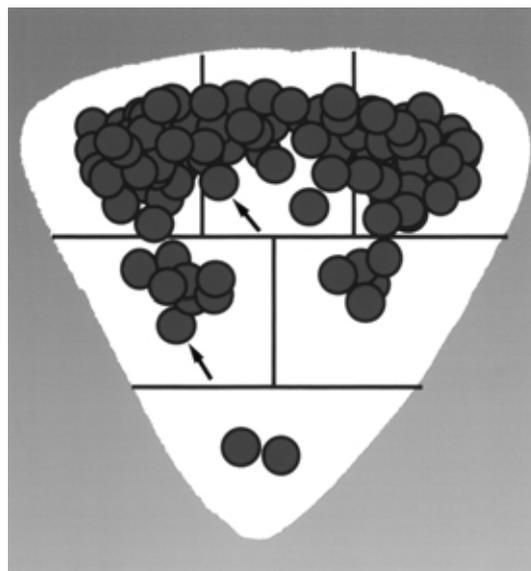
The location of E-GSs (arrows) was determined in a frontal view of the uterus with three-dimensional transvaginal ultrasound. The uterine cavity was divided into three parts: upper, middle, and lower regions. The upper region was subdivided into the right, middle, and left areas, and the middle region was subdivided into the right and left areas. Thus, overall 6 areas were designed.
